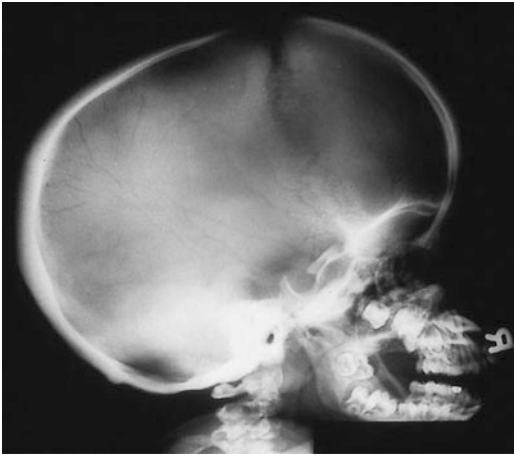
Skull radiograph showing a large scaphocephalic calvarium with early appearance of the J-shaped sella turcica
